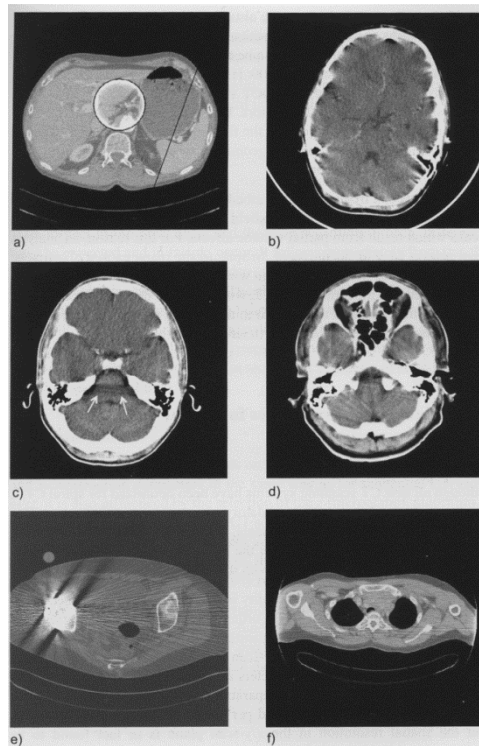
common CT image artifacts including (a) patient motion, (b) beam hardening, (c) partial volume, (d) metal implant (beam hardening), and (e) exceeding field of view. [5]
